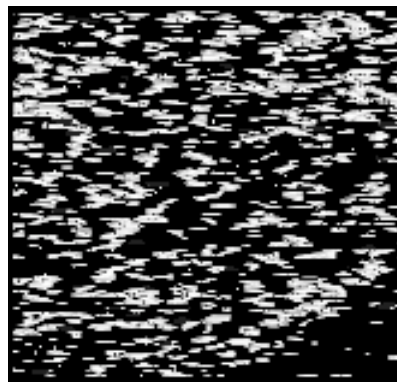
Three-dimensional rendering of a HRCT noise induced point process
